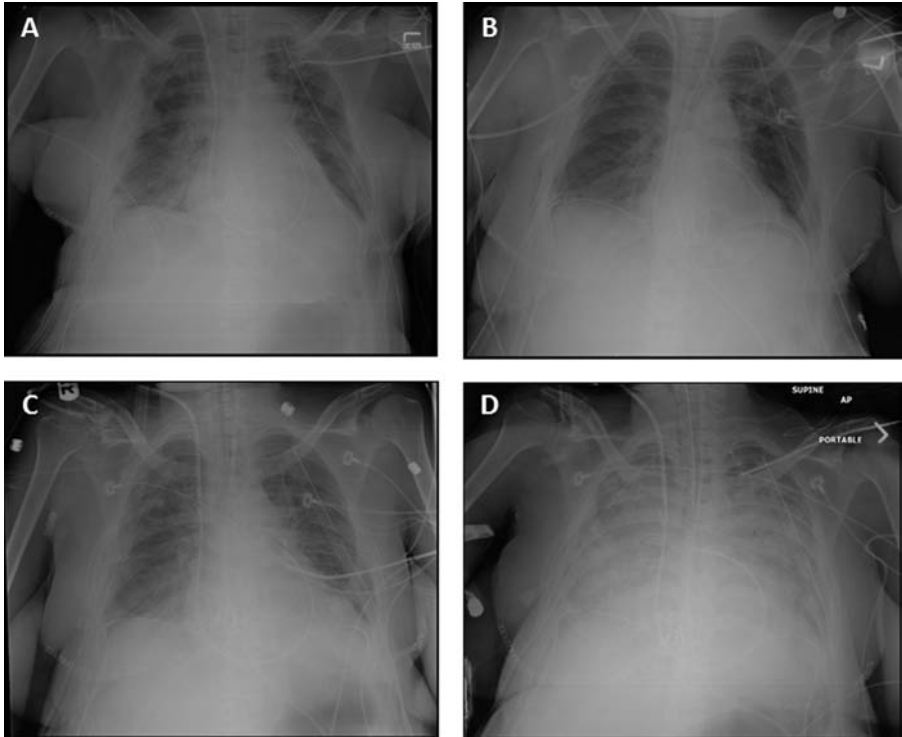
Radiographic progression of PGD after bilateral lung transplant. (A) Immediate postoperative chest X ray (CXR); (B) postoperative day 1; (C) postoperative day 2; and (D) postoperative day 3. Note mild diffuse pulmonary interstitial infiltrates forming on day 2, progressing to diffuse alveolar filling pattern on day 3.
